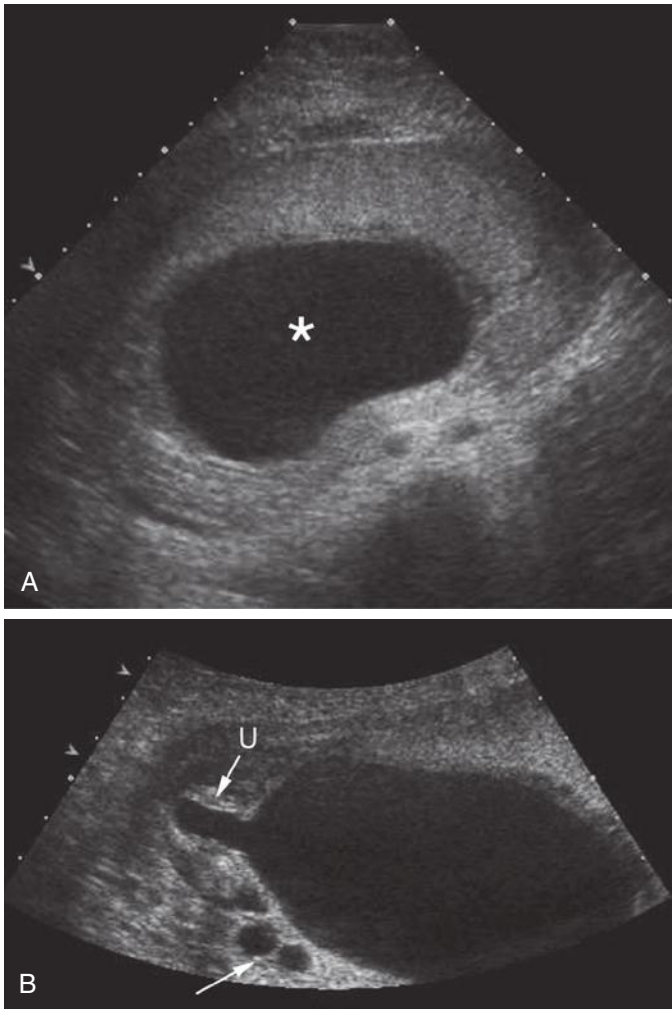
A, Large fluid collection (*asterisk*) appears to be amniotic fluid; however, it represents a markedly dilated urinary bladder in a patient with posterior urethral valves. In fact, there was virtually no amniotic fluid. B, Another sonogram in the same case demonstrates a dilated posterior urethra (U) and dilated ureters (*arrow*) in addition to the dilated urinary bladder.
